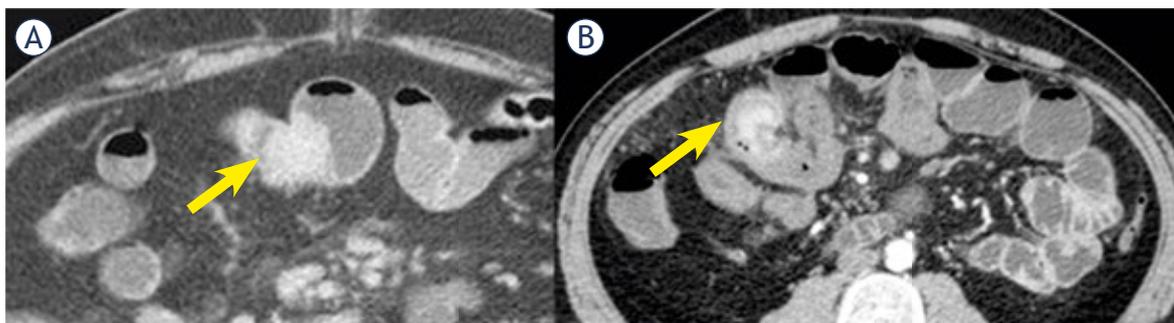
A 41 yrs old male. CT enteroclysis examination shows lesion, in (A), as small, hypervascular, polypoid (arrow) and, in (B), as an asymmetric bowel wall thickening (arrow).
